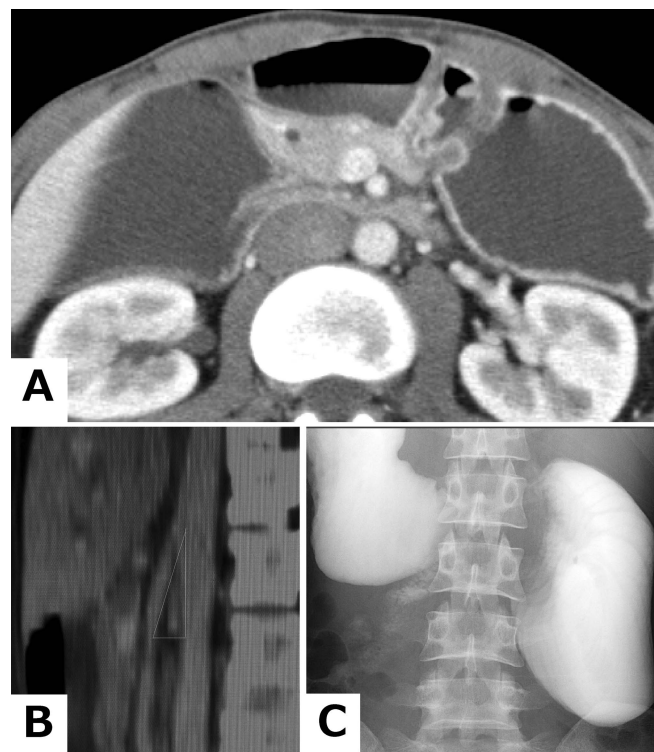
Imaging study during first admission. A. Coronal plane of the enhanced CT: a stricture of the duodenum on the oral side of the SMA. B. Sagittal plane of the enhanced CT: the aorta SMA angle was 16 degrees, the aorta SMA distance was 8 mm. C. Upper gastrointestinal series: dilatation of the stomach and duodenum was seen.
